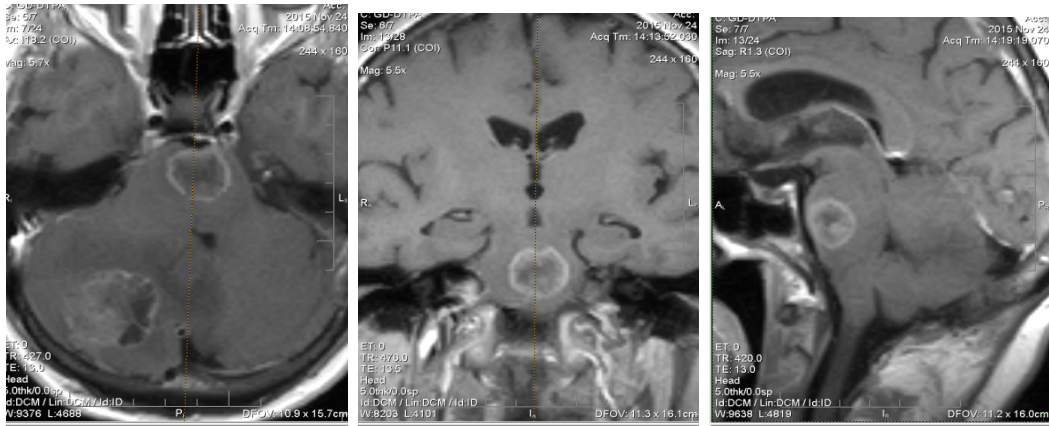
Case 2 - MRI T1 enhanced – two lesions: right cerebellar and in brainstem
